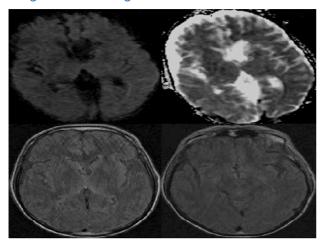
The lesions are regressed after the thiamine replacement on diffuse MRI and flair weighted axial images
